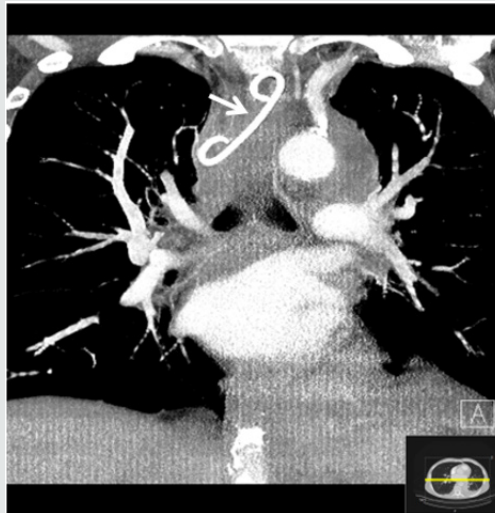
Maximum intensity projection CT imaging shows the position of pigtail drainage in the thoracic cavity.
